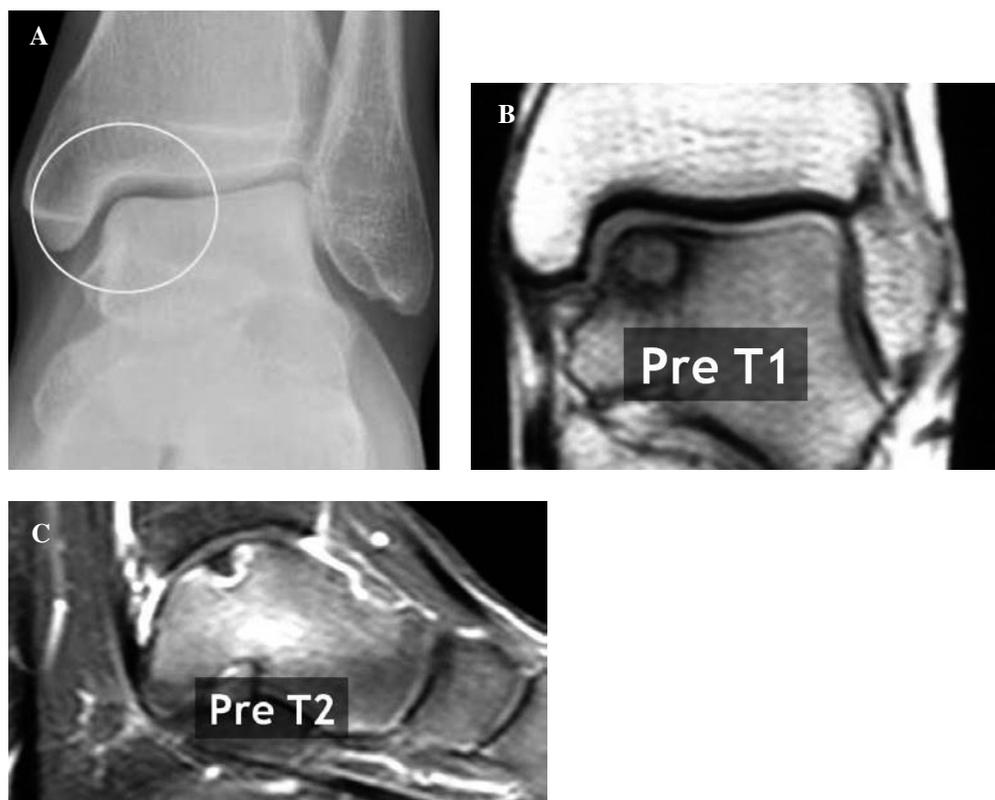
Radiograph and MRI images of an osteochondritis dissecans (OCD) tali at the medial talar edge (Berndt and Harty Stage II, Hepple and Winson Stage IIa): AP radiograph (A), coronal T1 reformation (B), and parasagittal T2 reformation (C).^{3,8}
